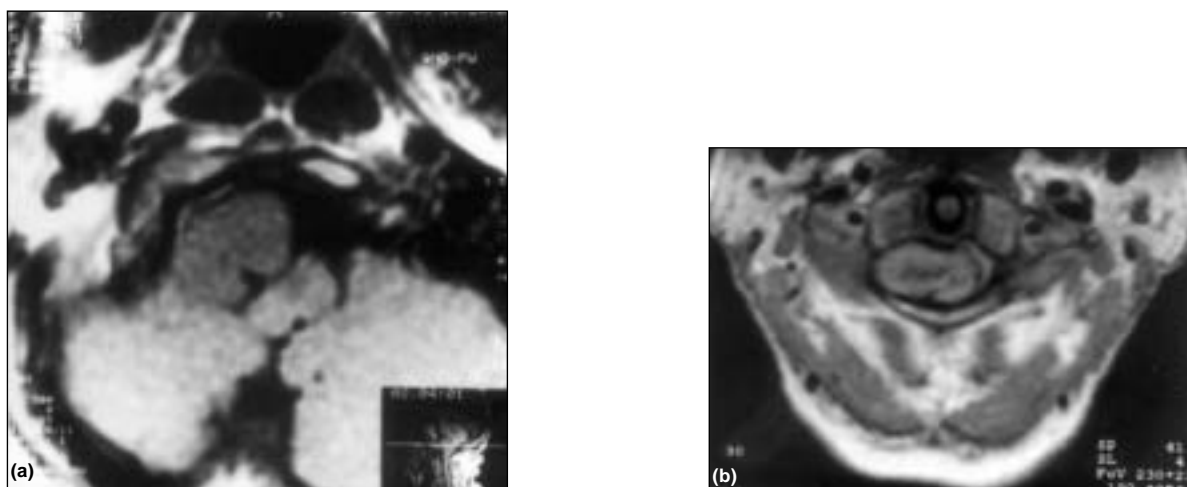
(a) T1-weighted axial MR image showing an anterolaterally placed tumor extending above foramen magnum pushing the cord posterolaterally; (b) T1-weighted axial MR image showing minimal extraspinal extension.
